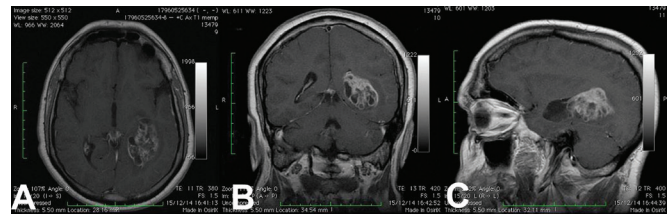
Preoperative (A) axial, (B) coronal and (C) sagittal sections of T1-weighted MRI of the patient showed a multiloculated contrast-enhancing mass lesion located in the left occipital horn of the lateral ventricle. There was no invasion into the surrounding brain parenchyma.
